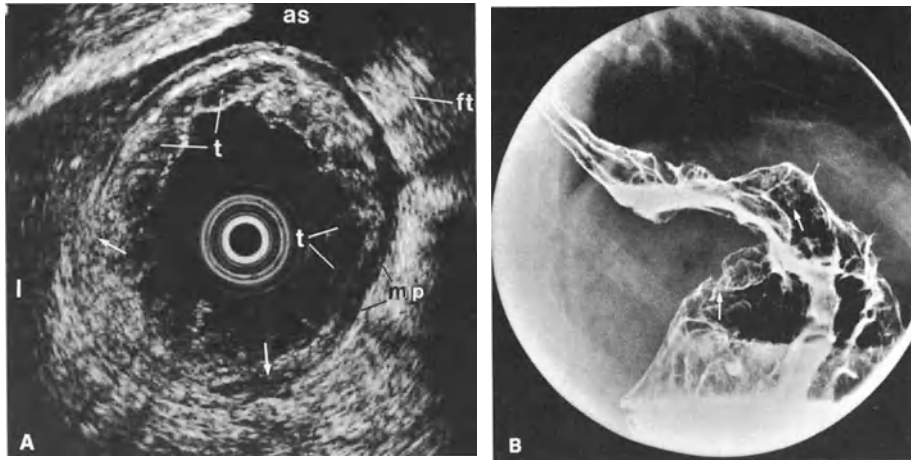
A Endoscopic sonogram showing diffuse hypoechoic infiltration into the submucosal layer (*t*) with some penetration (*arrows*) into the muscularis propria (*mp*) and thickening of the gastric wall associated with ascites (*as*). *l*, liver; *ft*, fat tissue. B Corresponding radiogram, showing a double contour in the proximal stomach (*arrows*)
